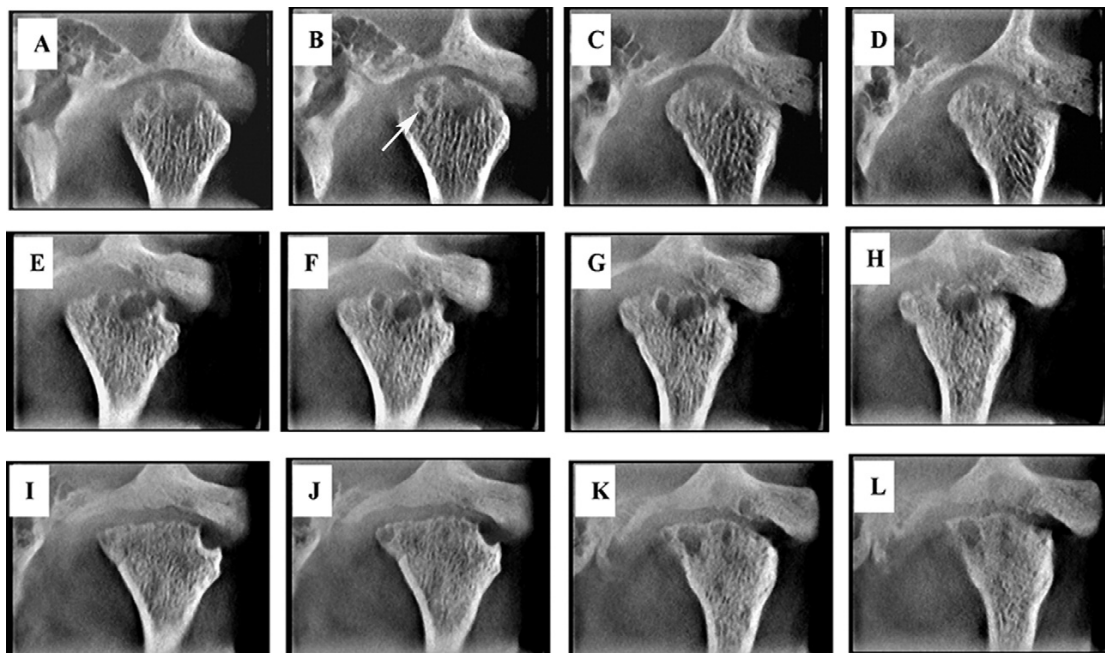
Cone-beam computerized tomography (CBCT) images of the left condyle. A-D, The first CBCT was in June 2006 and showed 2 cyst-like radiolucent lesions with the discontinuance of the articular surface, 1 cyst surrounded by a sclerostic rim
